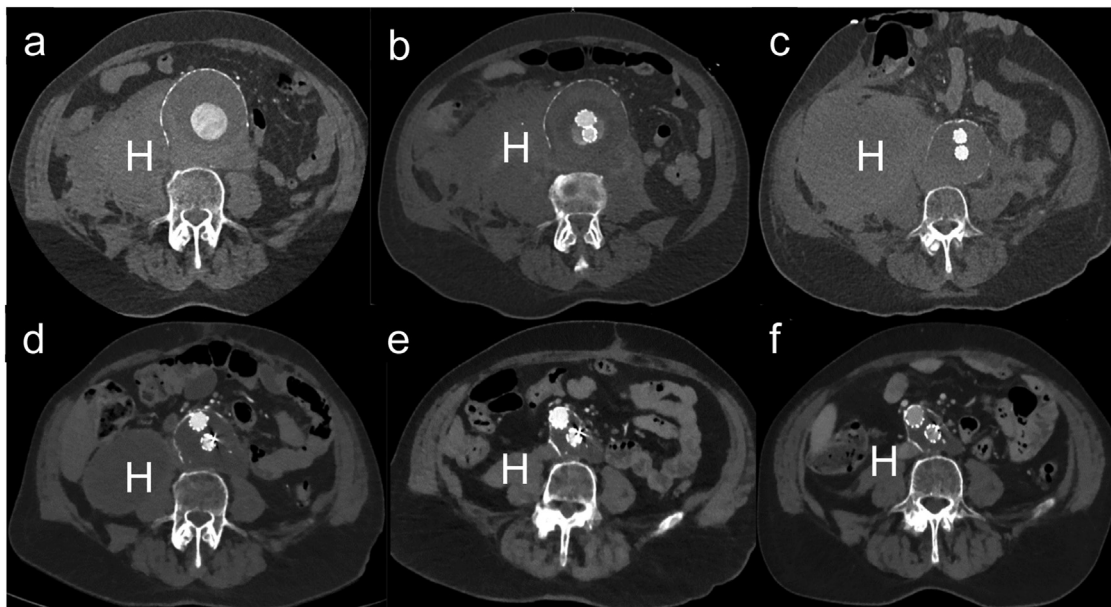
Computed tomography angiographies (CTA) of a hemodynamically stable 79-year old patient presenting with a contained rupture of an abdominal aortic aneurysm and large hematoma (H) in the right retroperitoneal space (a). Immediate CTA after endovascular aortic repair (4hrs after the initial CTA) revealed hematoma growth due to a deranged coagulation (b) which lead to an abdominal compartment syndrome few hours later treated with decompressive laparotomy and abdominal vacuum therapy (c). Intraoperative aneurysm sac incision revealed no endoleakage. The retroperitoneal hematoma was not evacuated due to the persistent deranged coagulation and large retroperitoneal area affected. The hematoma shrunk spontaneously during further follow-up (d: after 2.5 months; e: after 1 year; f: after 2 years) without the need for evacuation or drainage.
